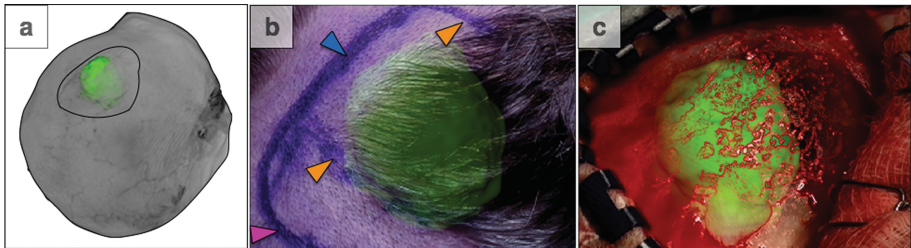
(a) Case 1: 3D rendered MRI skin surface (from the back, with the patient's neck directed towards the top of the image) and segmented tumour virtual patient model, showing position of patient head and approximate location of the planned craniotomy. (b) In this case the tumour outline indicated by the orange arrow was done using the Medtronic system and checked using AR. There was a good correspondence between the AR view and the outlined tumour. The blue arrow indicates the boundary of the tumour and overlaps with the contour of the planned skin incision. The pink arrow indicates the superior boundary of the planned skin incision. (Color figure online)
